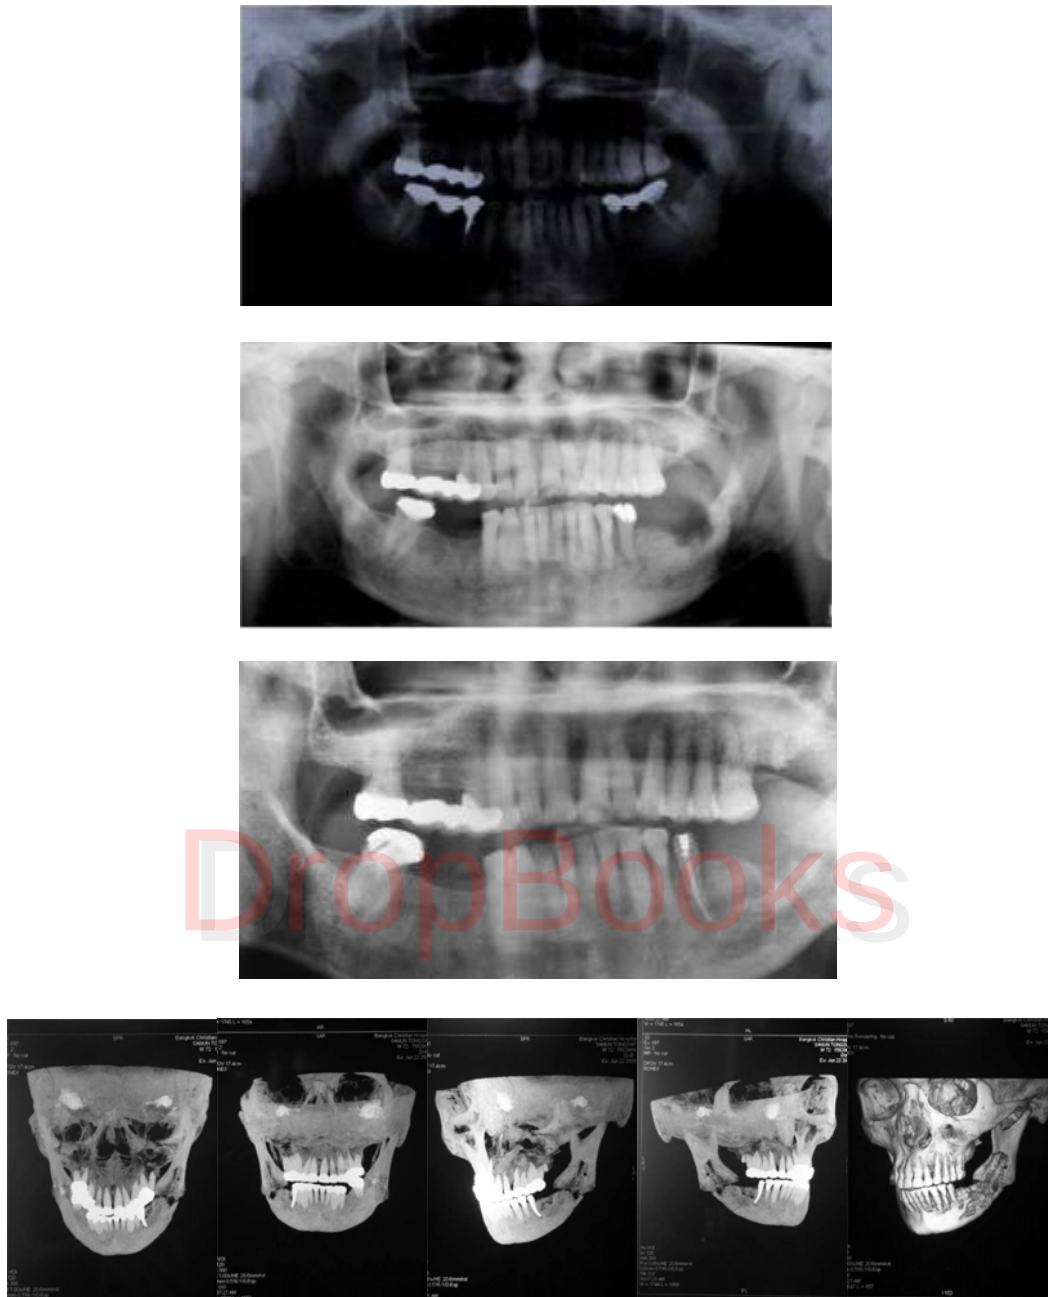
Panoramic radiographic images of the mandible before tooth extraction (A), osteoradionecrosis developed at the extraction site (B), sequestrum of the mandible (C), Anterior, posterior, buccal, and lingual view of 3D CAT Scan demonstrated pathologic fracture in ORN patient (D).
